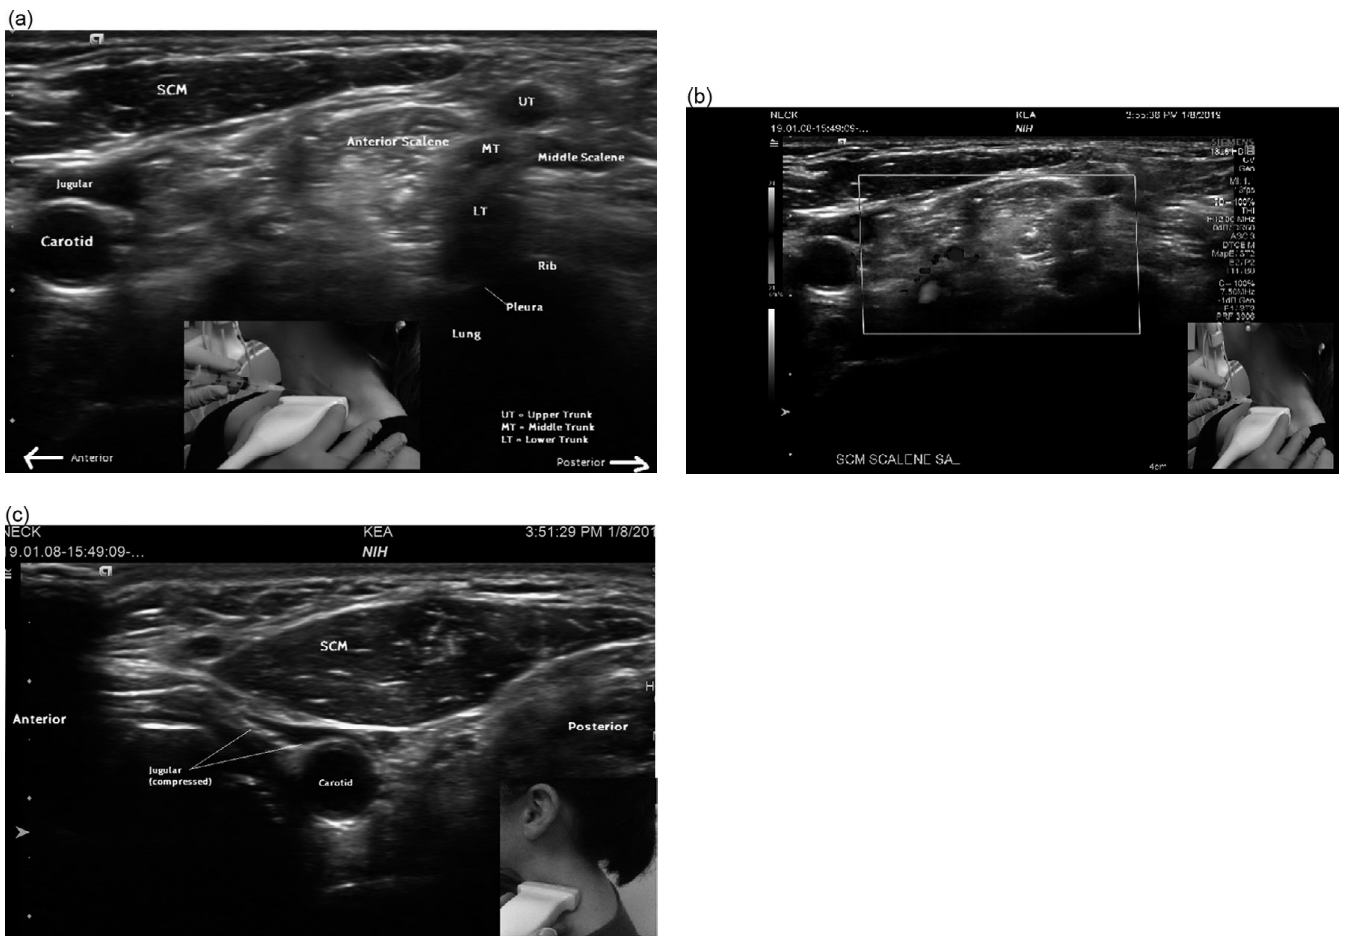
(a) Short-axis (transverse) B-mode scan anterolateral neck (transducer location/orientation interscalene triangle). (b) short-axis color Doppler image, interscalene triangle. (c) Short-axis (transverse/cross-sectional) view sternocleidomastoid muscle (inset:transducer location/orientation).
